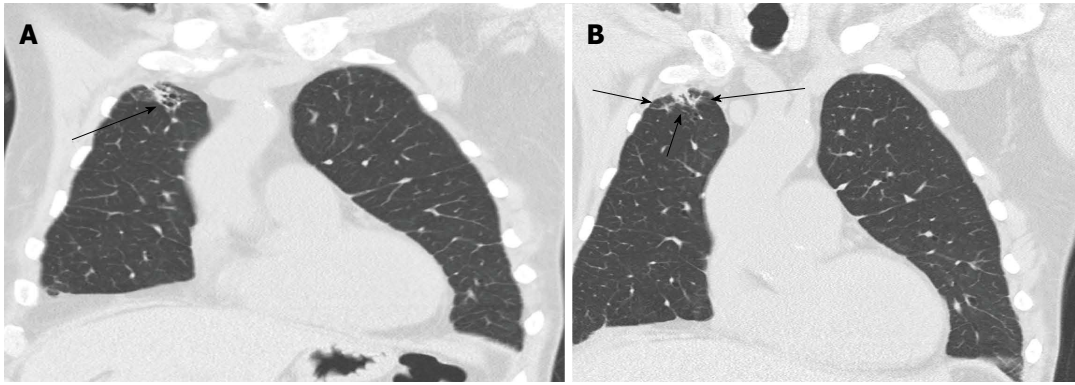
Broncho-alveolar lavage proven aspergillosis. CT scan of the chest shows right lung apex sub-pleural nodule with surrounding ground glass opacity and focal bronchiectasis. A: Coronal slice of CT chest showing right apical sub-pleural nodule (arrow); B: Coronal slice of CT chest showing surrounding ground glass opacity and focal bronchiectasis (arrow) around a sub-pleural nodule. CT: Computerised tomography.
